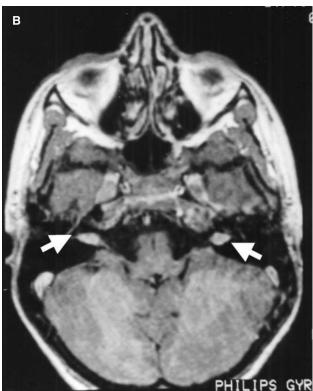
(A–B) axial T2-weighted brain MR images showing the progression of a vestibular schwannoma from a single (right) lesion (A, white arrow) to a bilateral middle sized lesions (B, white arrows).
